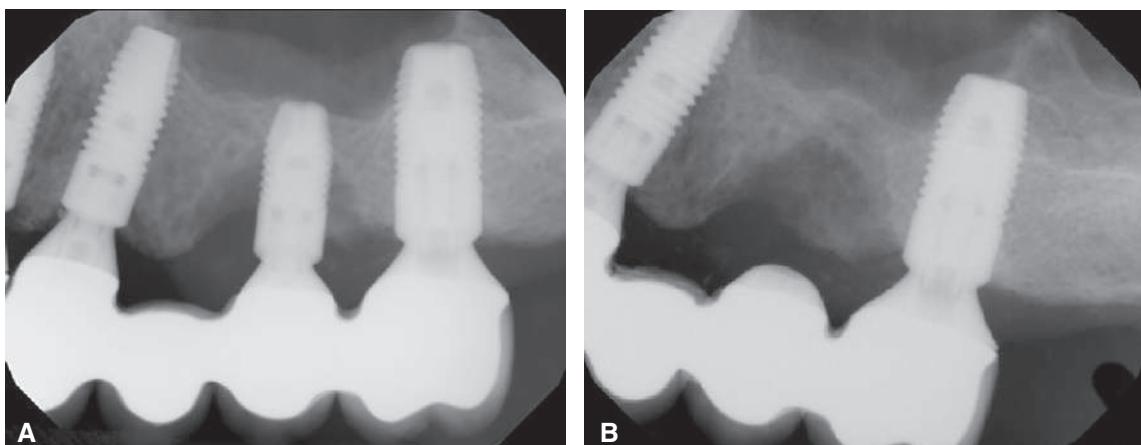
(A) A fixed partial denture (FPD) supported by three dental implants. The failing premolar dental implant has deep pocketing, localized radiographic bone loss, and suppuration. (B) It was decided to tap the FPD off and remove the failing implant before it affected the proximal implants. Its titanium custom abutment was permanently cemented back into the FPD and the engaging implant part of the abutment was sectioned off and polished into the shape of an ovate pontic. Once an ideal ovate pontic was formed, the FPD was cemented back into service.
